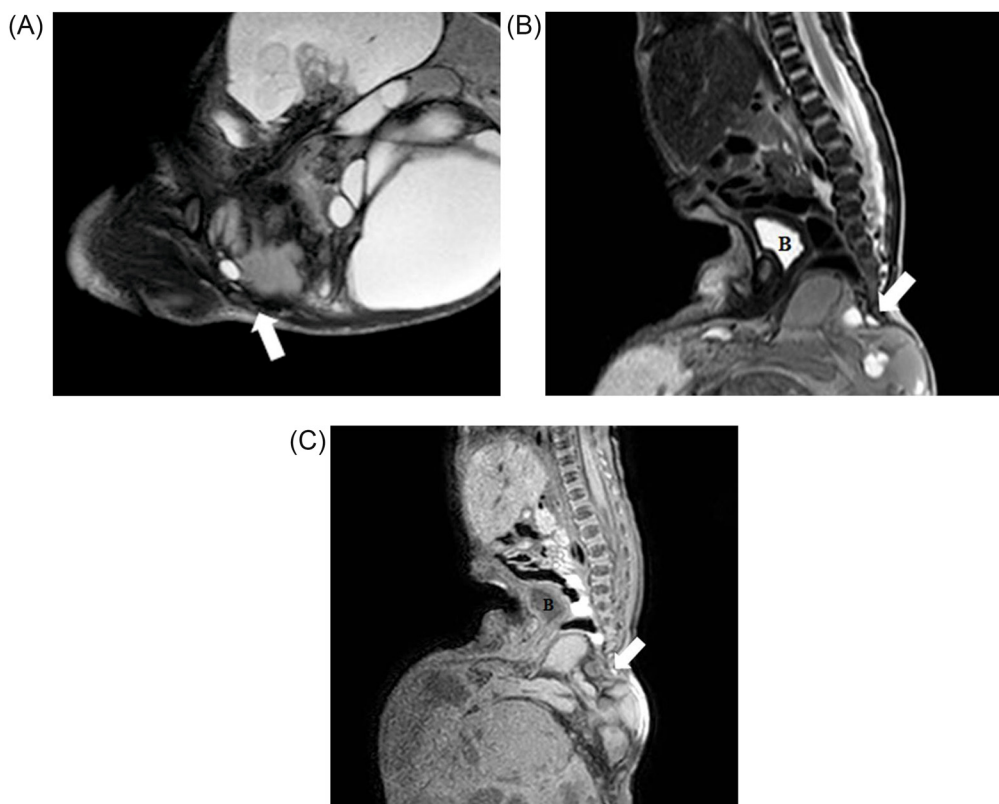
(A-B-C) Axial T2-weighted (A), sagittal T2-weighted (B), and sagittal T1-weighted post-gadolinium (C) images demonstrate a huge precoccygeal multicystic mass located postero-inferior to the bladder. A well-defined plane of cleavage between the tumor and the anterior surface of the last coccygeal vertebrae was not appreciable, but there was no invasion of the spinal canal (white arrows).
